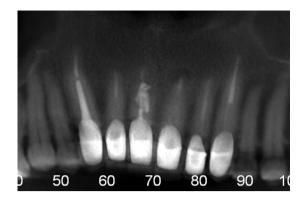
Nine-month follow-up panoramic radiograph.
